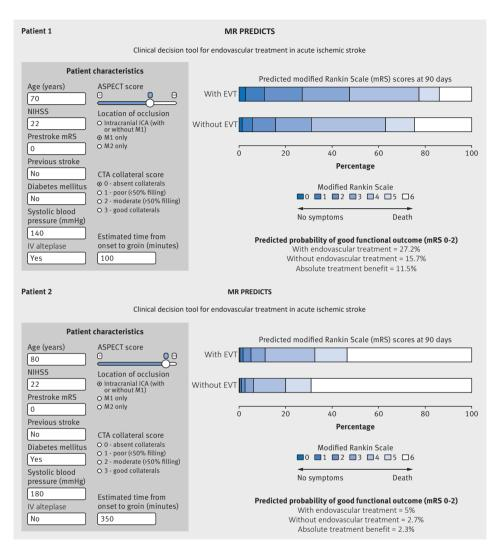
A stylized representation of the clinical decision tool. Baseline characteristics and predicted probabilities of good functional outcome (modified Rankin Scale (mRS) score 0-2) for two examples (see introduction). ASPECT, Alberta Stroke Program Early Computed Tomography Score; EVT, endovascular treatment; NIHSS, National Institutes of Health Stroke Scale; ICA, internal carotid artery; CTA, computed tomography angiography.
